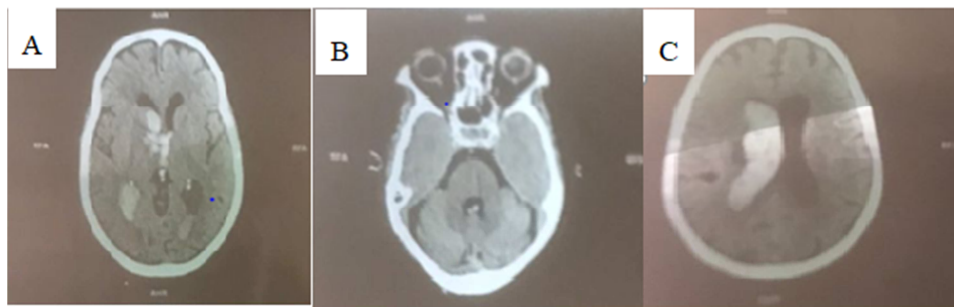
Brain CT scan images. A: Spontaneous hyperdensity thalamo-caudate and in third and right occipital horn ventricle. B: Hyperdensity in the fourth ventricle. C: Hyperdensity in the right lateral ventricle.
